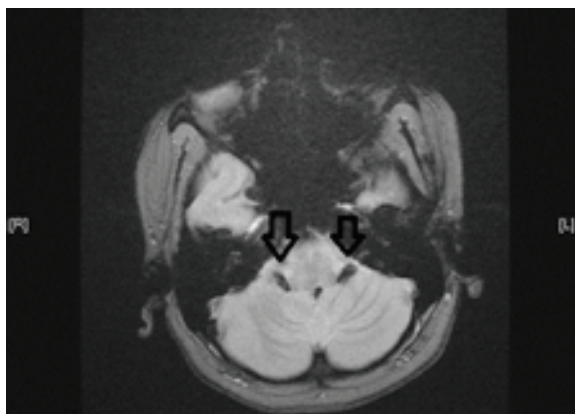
MRI Brain – GRE image showing hypointensity of Foramen of Luschka
